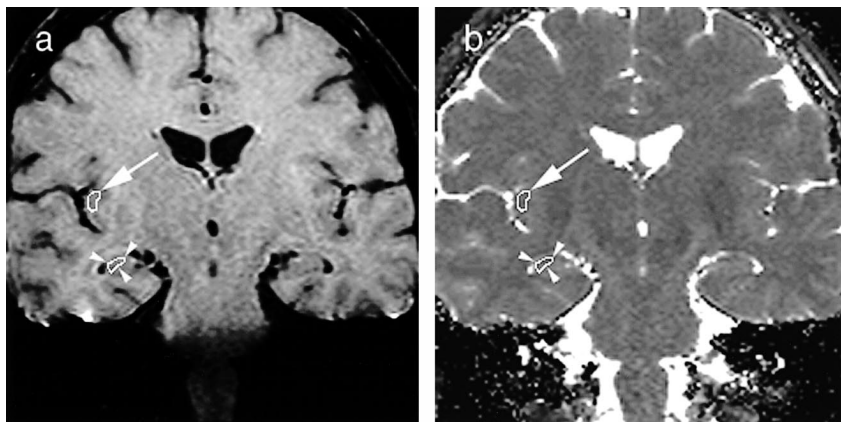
First-echo oblique coronal MR images (1000/25) of the brain, with variably sized ROIs placed in the insular cortex (arrow) and hippocampus (arrowheads).
